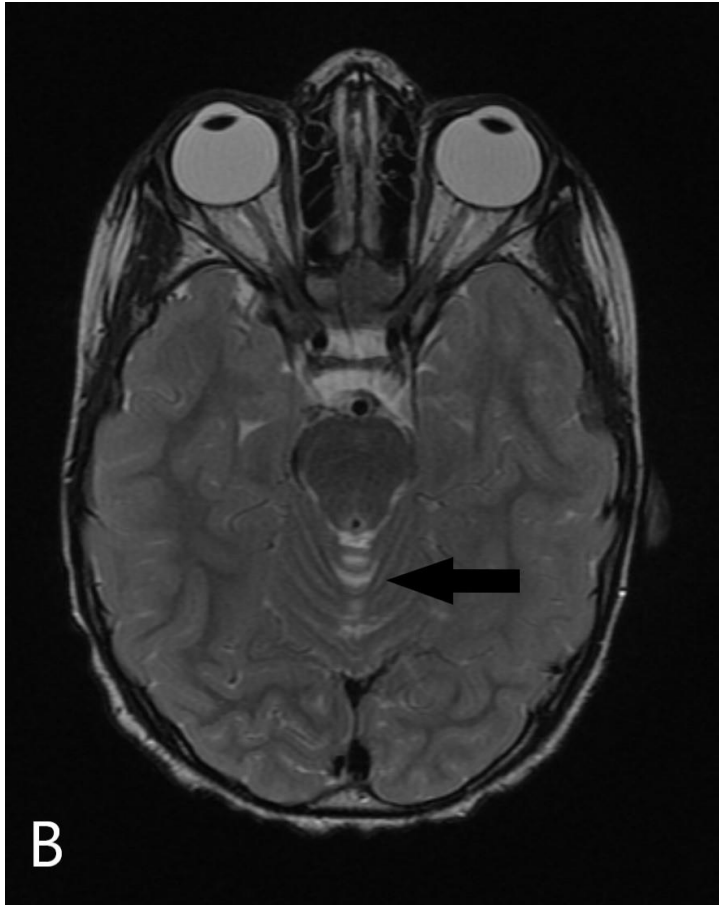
Selected images of Child 2. A axial T2 image through normal basal ganglia. B axial T2 image through the superior cerebellar demonstrates increased T2 signal in the superior vermis. C Coronal T2-FLAIR image through the vermis demonstrating increased signal in the vermis. D Sagittal T1 in the midline demonstrating loss of volume of the superior vermis.
